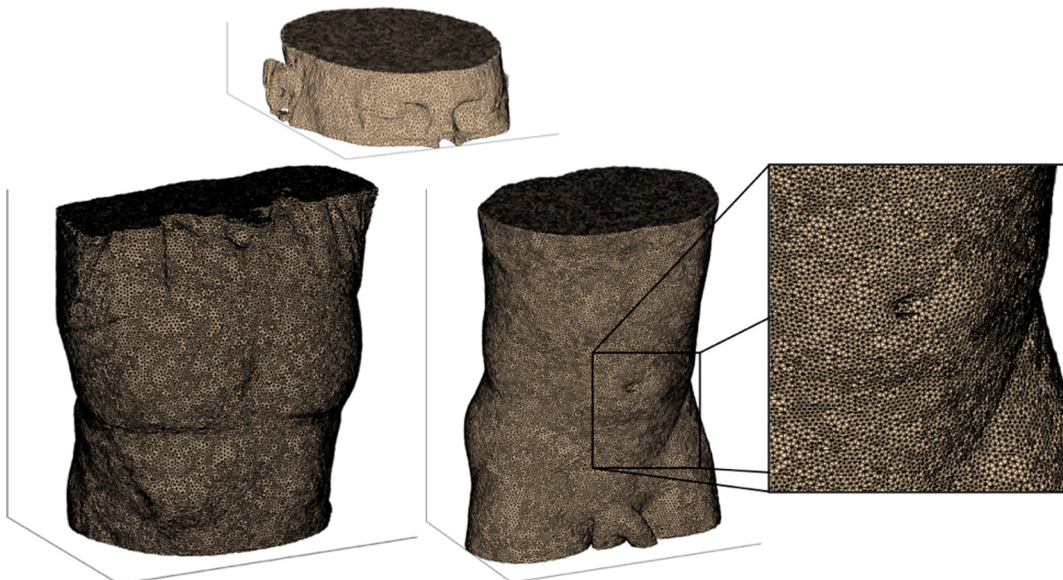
An example set of volumes reconstructed from head, chest, and abdominopelvic CT datasets.
